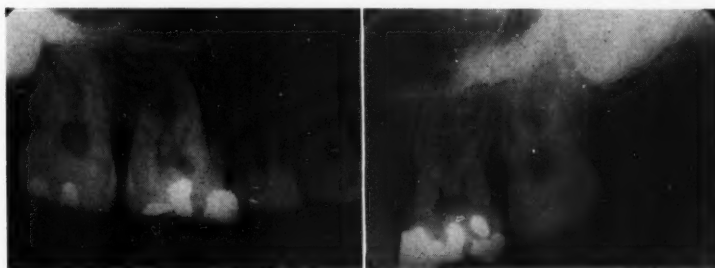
Patient J. H. Intraoral radiograph of right and left maxillary right first molars with partial resorption of distal and lingual roots.
